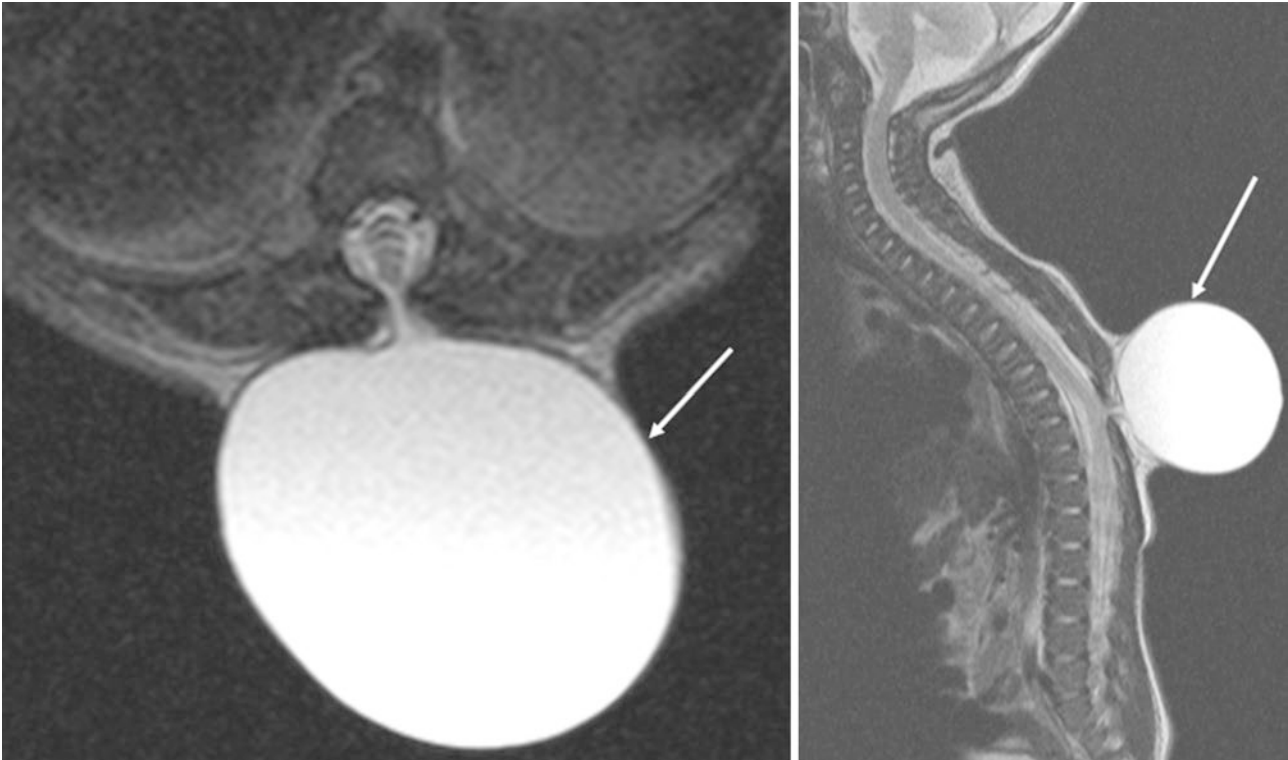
Axial and sagittal T2-weighted images of the thoracic spine in this one-day-old girl demonstrate spina bifida with thoracic meningocele (arrows). Notice the widening of the posterior elements of the thoracic vertebra at this level with the communication of meningocele with the CSF in the spinal canal
